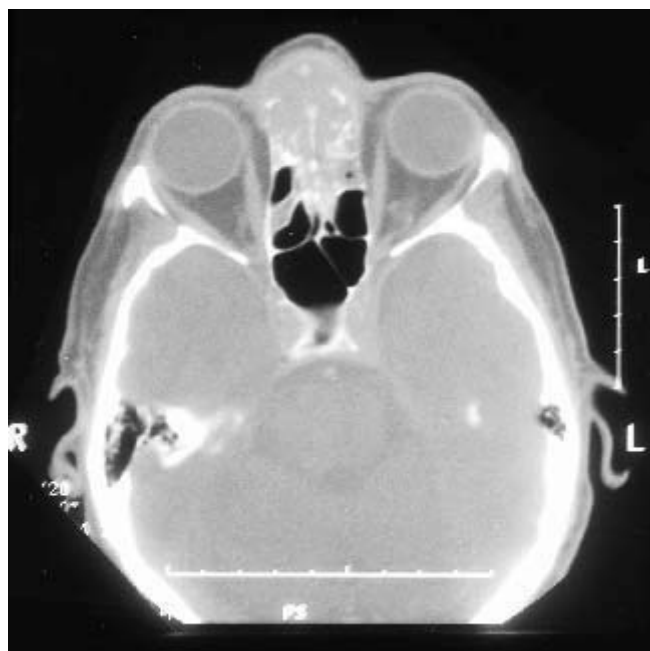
Axial CT scan showing tumour involving the anterior nasal cavity, nasal septum and right ethmoid cells.
